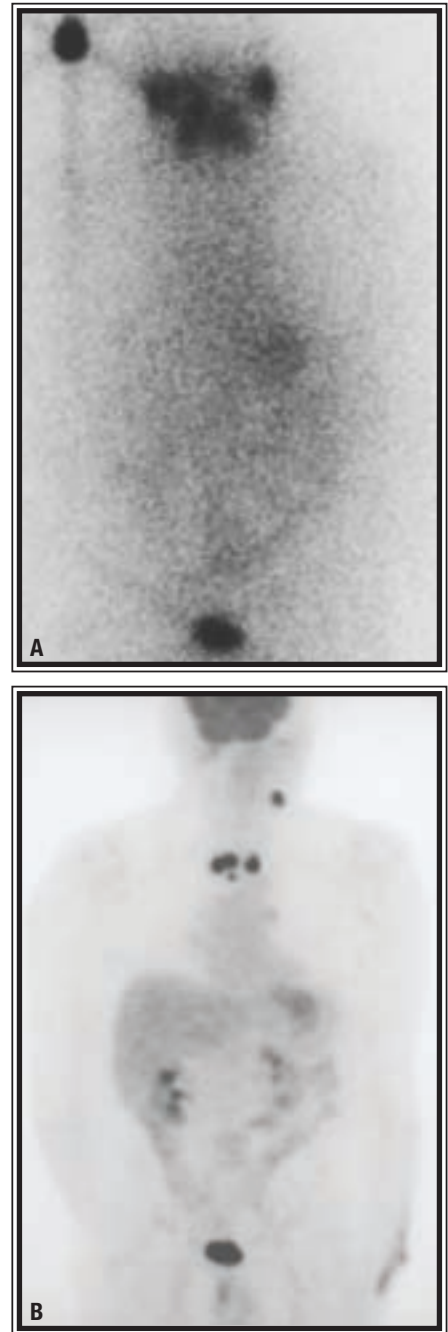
71-year-old man with history of follicular thyroid cancer presented with elevated thyroglobulin. A: Negative radioactive iodine scan. B: FDG-PET shows left neck level-1 and multiple superior mediastinal lymph nodes. Patient underwent successful PET probe-guided lymph node dissection in both regions.
